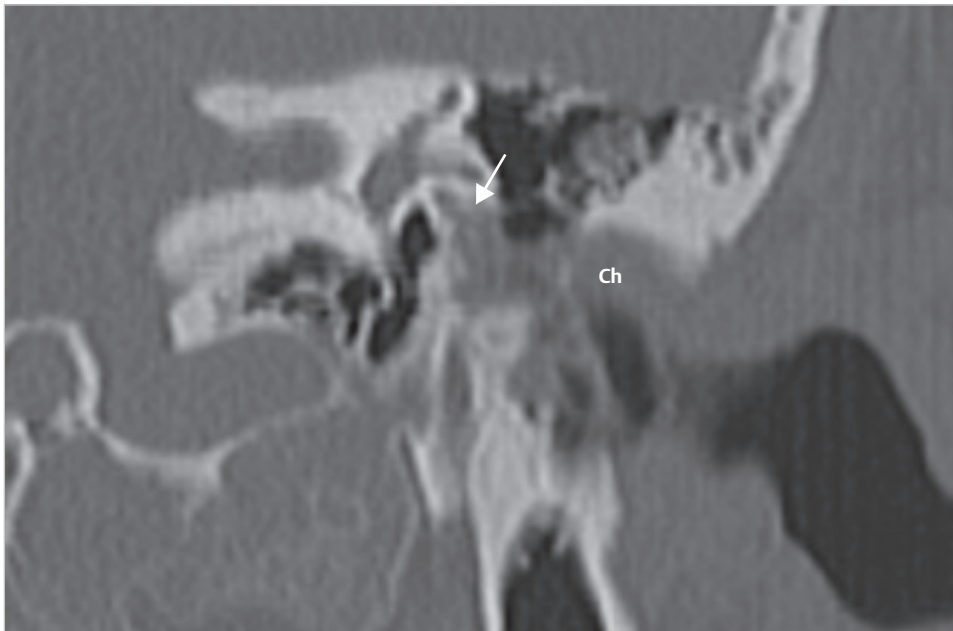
The coronal CT indicates that the cholesteatoma penetrates the posterior wall to open the mastoid air cells. Erosion of the fallopian canal is also demonstrated. Ch, cholesteatoma.
